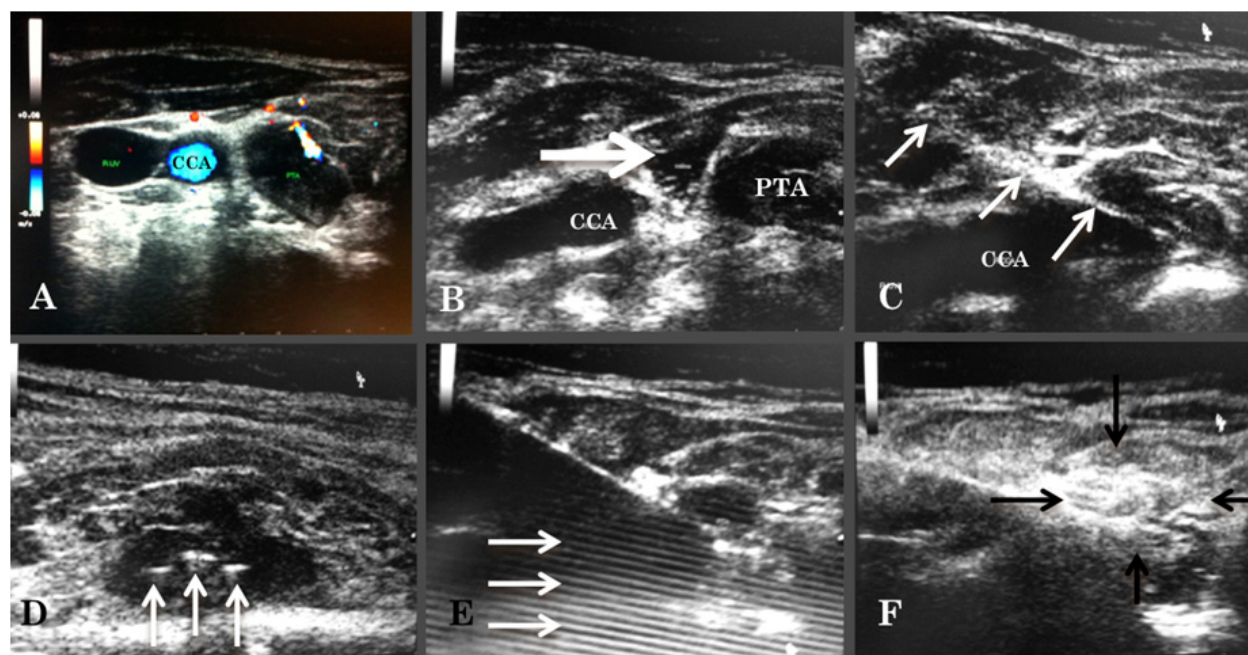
Radiofrequency ablation of parathyroid adenoma .A, Transverse sonogram of neck shows 15x10-mm right inferior parathyroid adenoma (PTA) .B; Sonogram of the neck after inflation of 5 ml saline (white arrow) to separate the PTA from the right common carotid artery (CCA). C ; Sonogram shows 25-gauge needle (arrows) inserted into parathyroid adenoma . D; Sonogram shows fans (arrows) of the radiofrequency probe within the PTA . E ; Sonogram during RFA of PTA shows reverberation artifacts (arrows) posterior to the needle) . F; Sonogram at the total RFA of the PTA, The ablated gland (arrows) appears echogenic.
